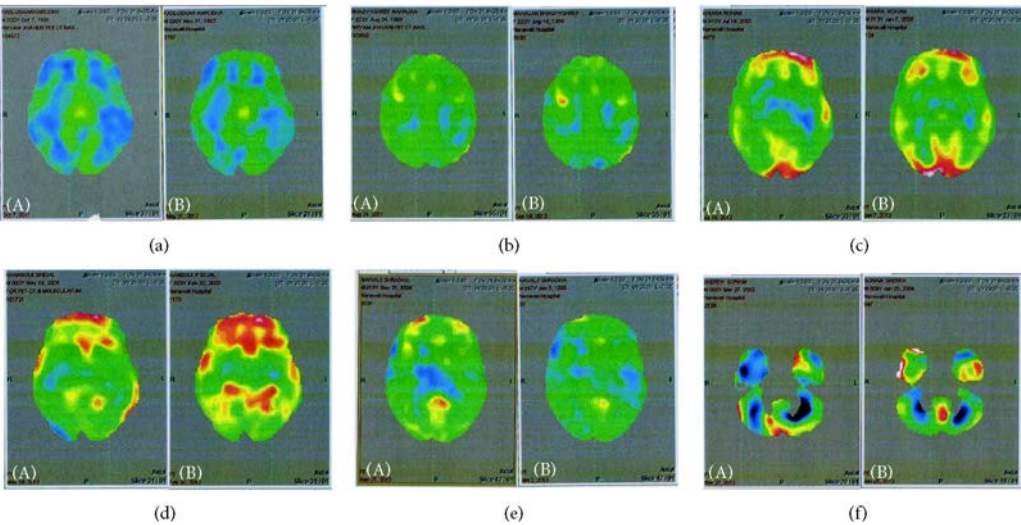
Improvement in PET CT scan
